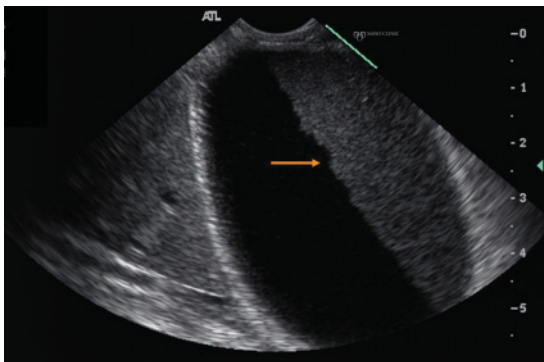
Linear endoscopic ultrasound image of a gall bladder with dependent non-shadowing sludge (arrow).
